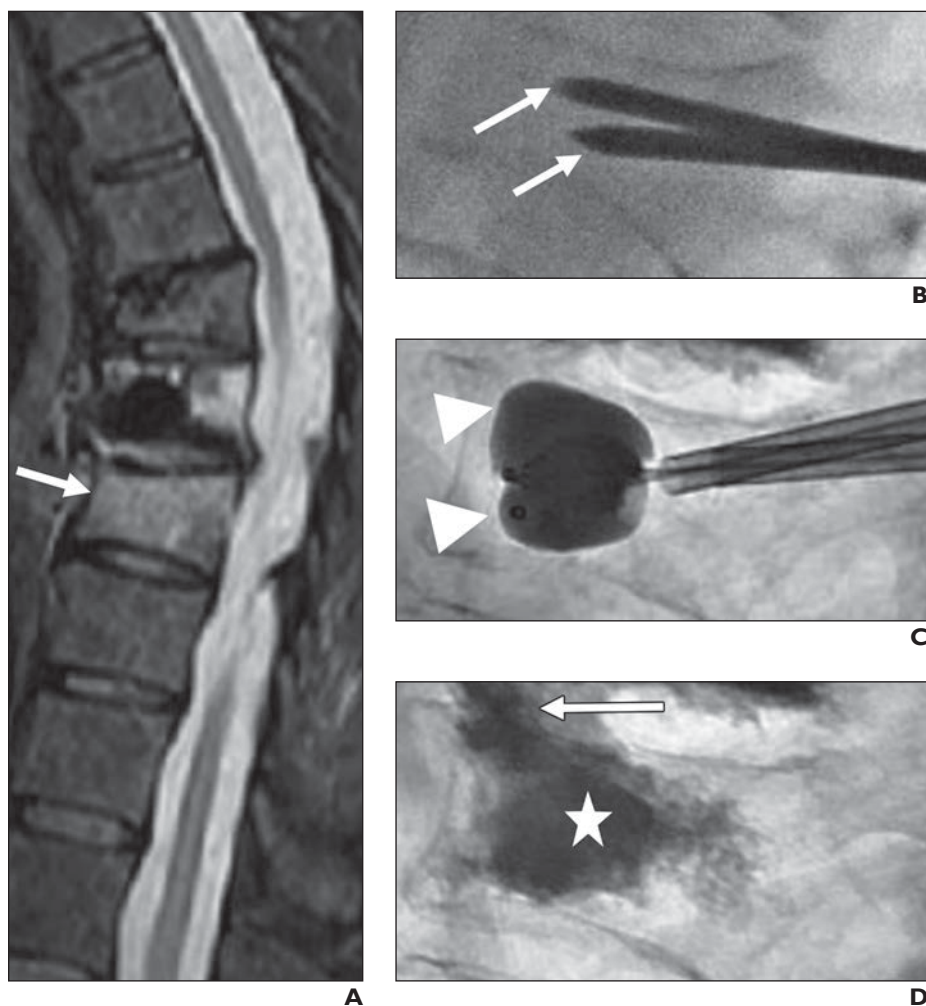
Vertebral compression fracture and kyphoplasty in 70-year-old woman with mid back pain. A, Fat-saturated sagittal T2-weighted MRI of thoracic spine shows edema in T8 vertebral body (arrow) with mild compression, suggestive of acute fracture. B–D, Intraoperative lateral spot fluoroscopic images of T8 vertebral body show needle tips (arrows, B) at junction of anterior and middle thirds of vertebral body, balloons fully inflated (arrowheads, C), and adequate amount of cement in vertebral body (star, D). Minimal cement extravasation into disk space (arrow, D) is seen, which is usually inconsequential.
